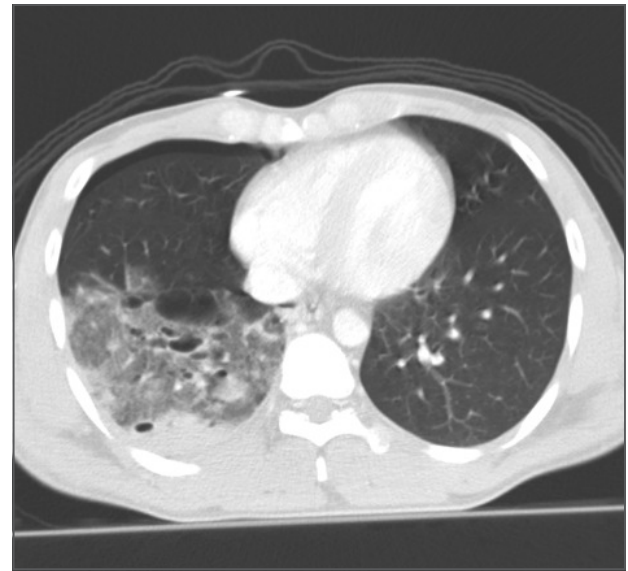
CT-Thorax. lung contusion, pneumatoceles and pneumothorax.
